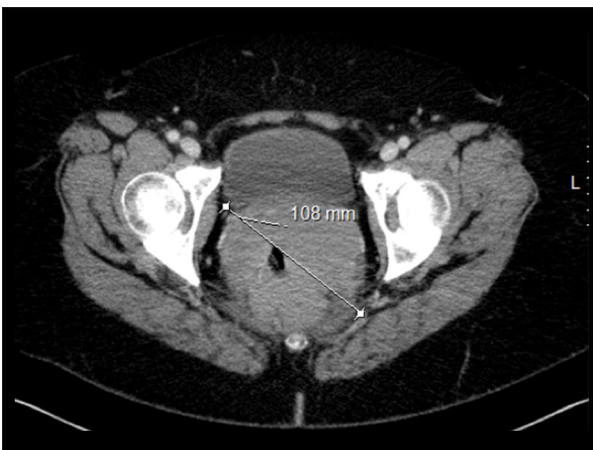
CT scan showing a 10.8-cm diameter circumferential mass encasing the low to high rectum to the level of the rectosigmoid junction with apparent infiltration to the anorectal junction.
